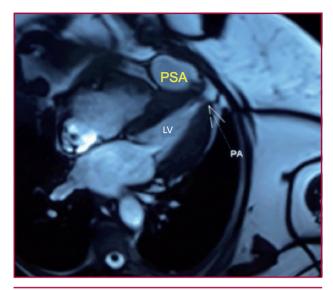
Magnetic resonance imaging axial plane emphasizing the neck of the defect. LV: Left ventricle. PSA: Pseudoaneurysm.
